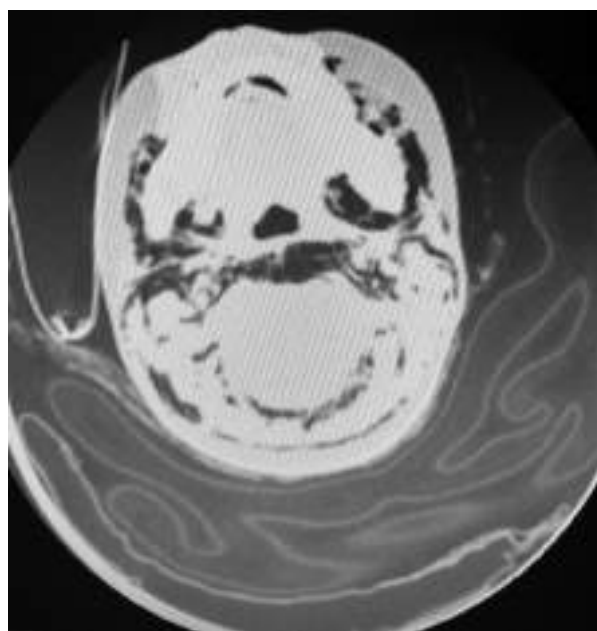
CT of the head (suprahyoid neck region) shows subcutaneous and deep neck emphysema
